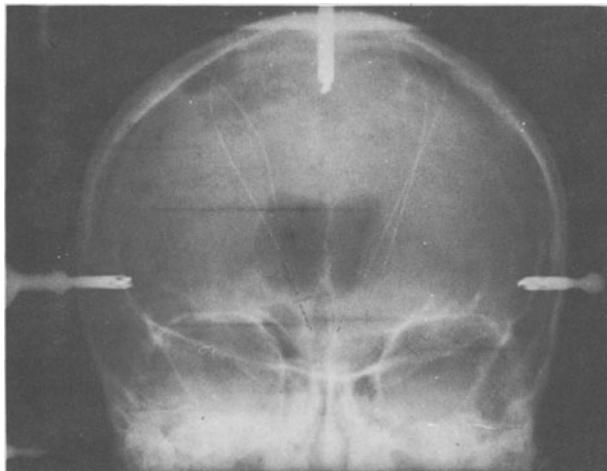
A.P. X-ray view taken during surgery showing the multilead electrodes in position
